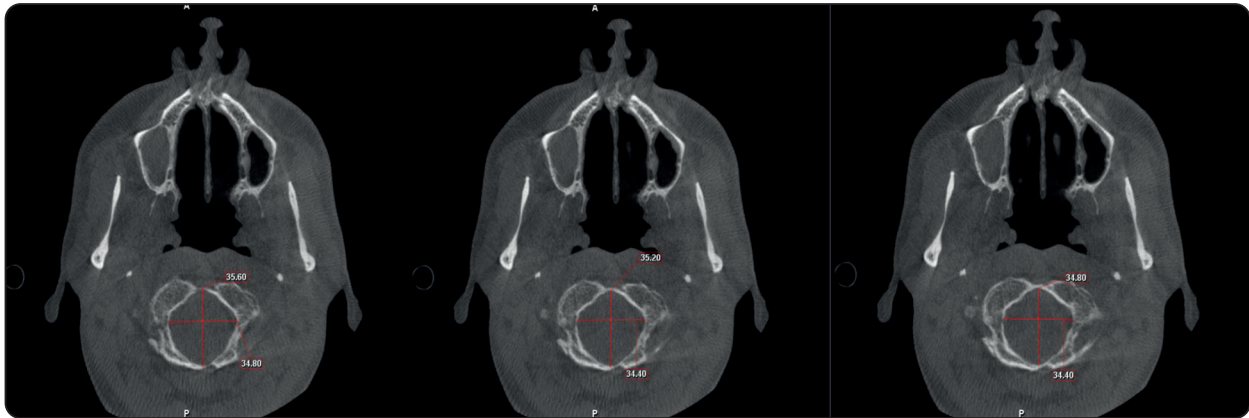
The measurement of the length and width of the foramen magnum on three successive axial CBCT cross-sectional images
